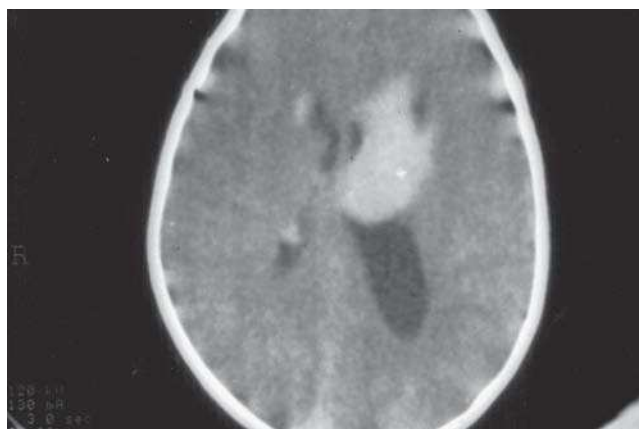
Case 4. Axial section of a neonate computed tomography (CT) scan, showing a tumour in the left lateral ventricle with dilatation and blocking.
